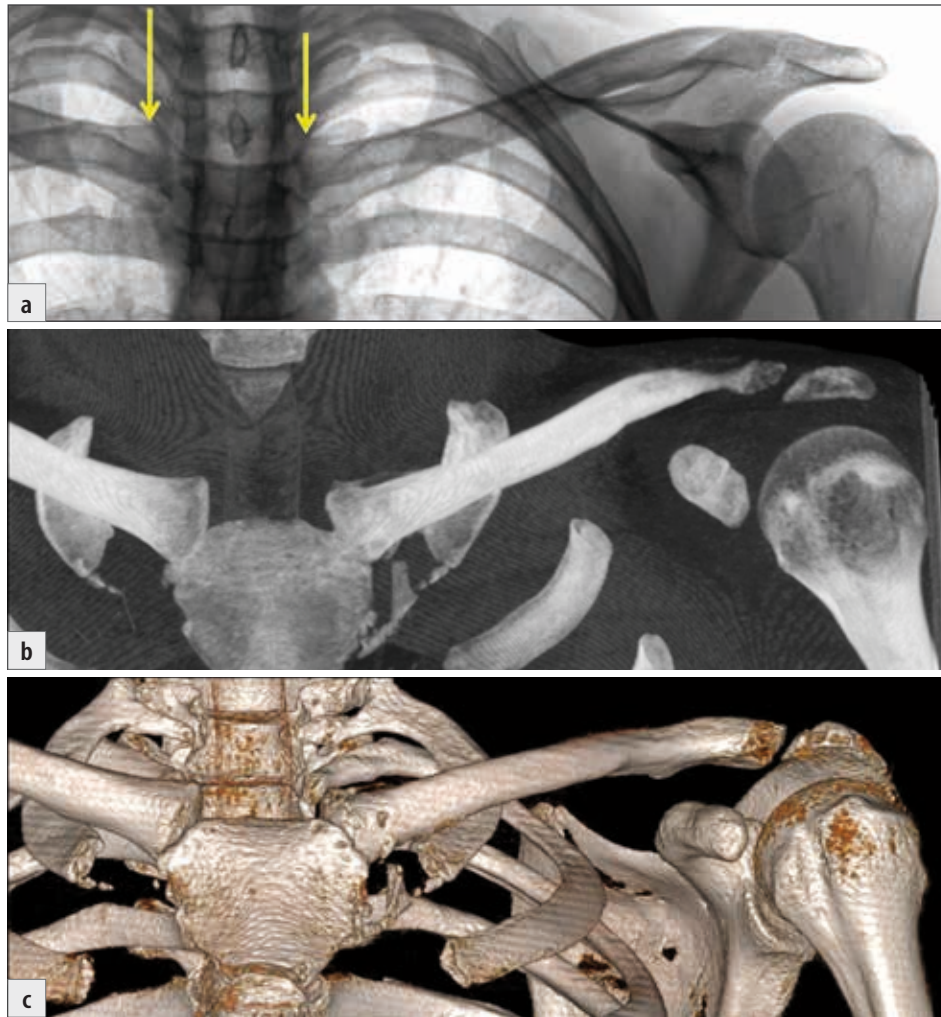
The case shown in Fig. 17-4 on CT: a) preoperative radiograph (arrows show the position of the sternal end of the clavicle; b) postoperative CT; c) postoperative 3D CT reconstruction.
